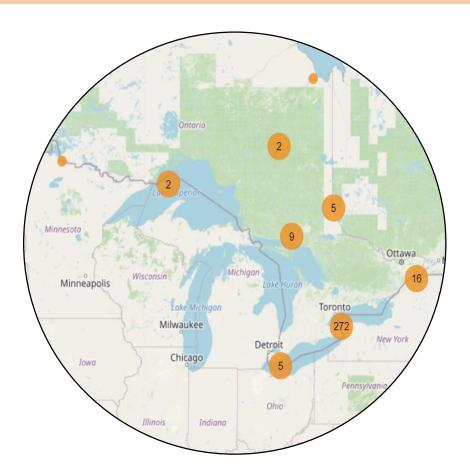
Map of ultrasound facilities in Ontario offering nuchal translucency ultrasound.
